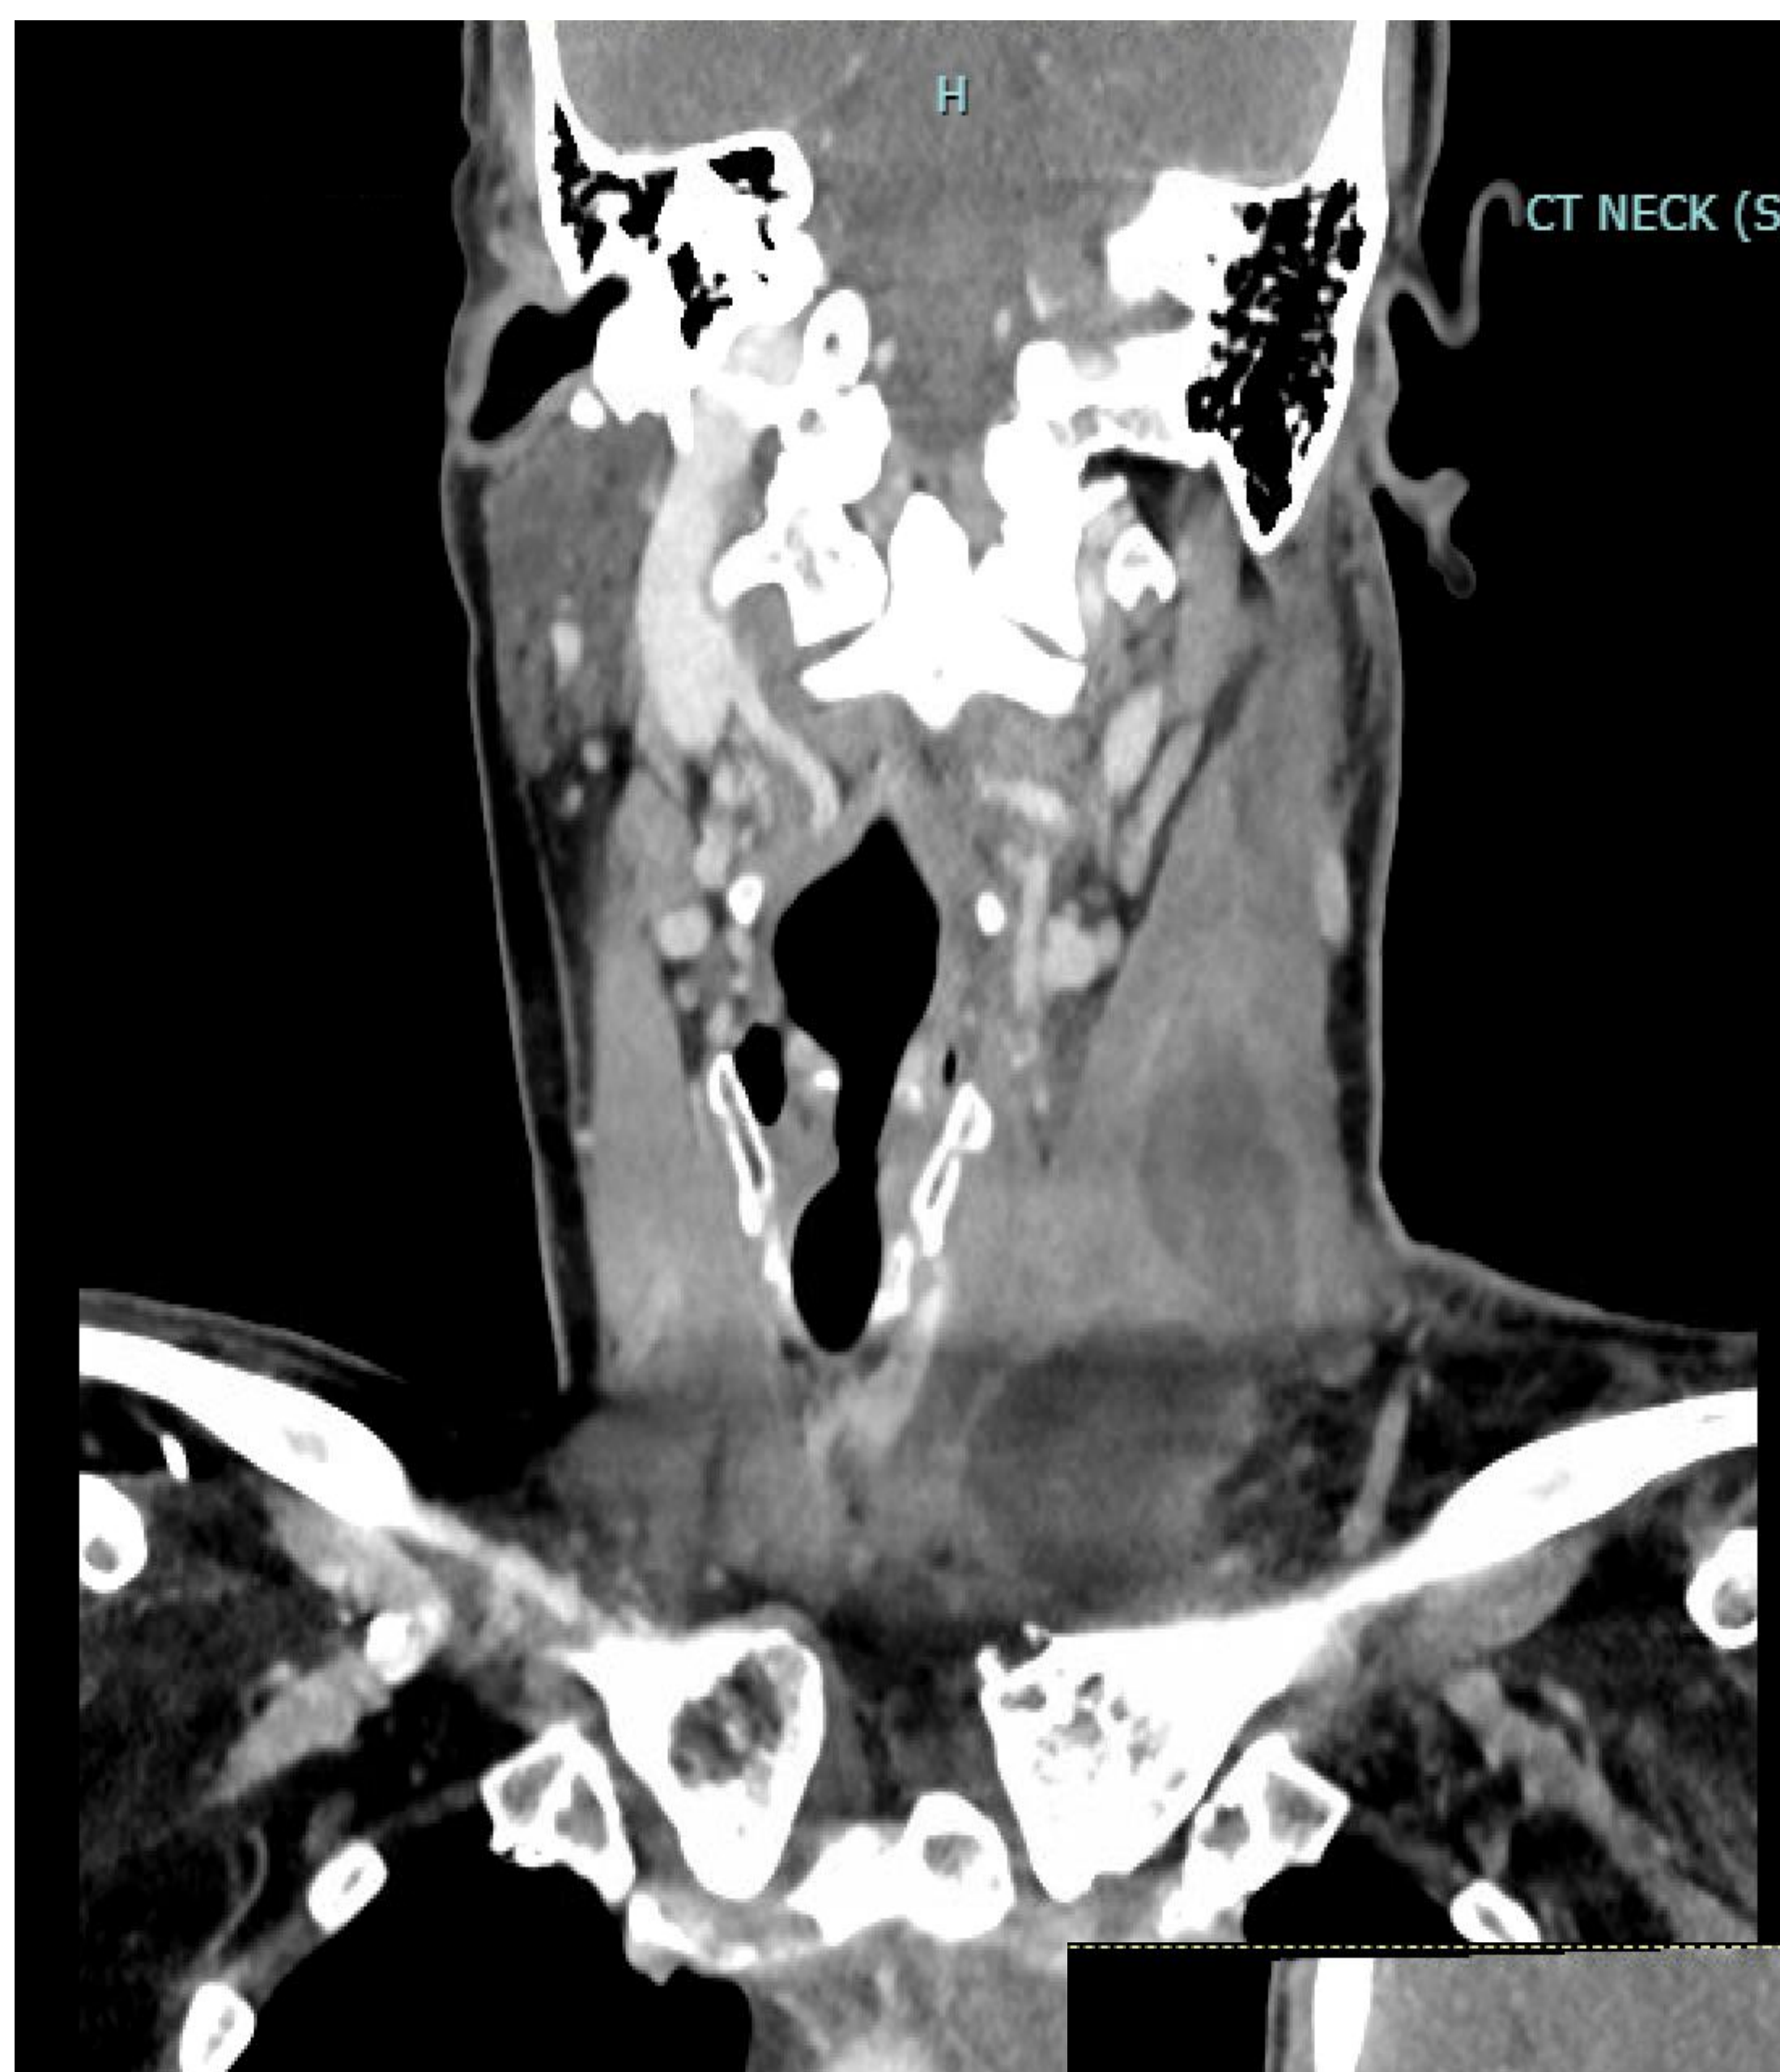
Coronal CT Neck from prior admission demonstrating multi-loculated retropharyngeal abscess in the left neck with soft tissue structure communicating with underlying sternoclavicular joint.
